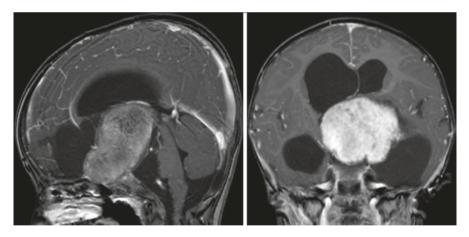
Optic pathway glioma: Sagittal and coronal T1-Gad MRI showing a large chiasmatic-hypothalamic glioma in a 16-month-old. The tumor was subtotally resected, followed by a shunt and chemotherapy
